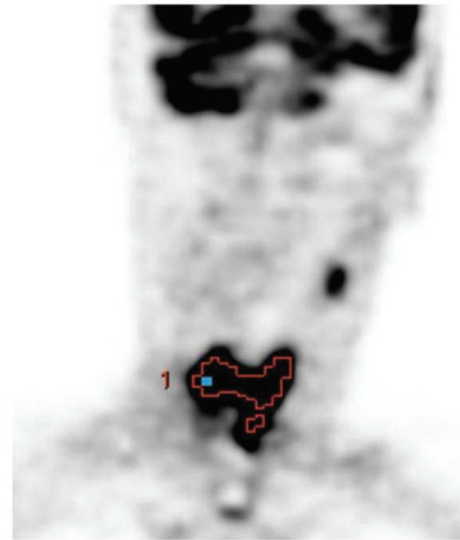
<sup>18</sup>F-2-fluorodeoxyglucose positron emission tomography/computed tomography image of a 67-year-old male with hypopharyngeal squamous cell carcinoma ( $SUV_{max}$ , 26.8;  $SUV_{mean}$ , 16.2;  $SUV_{peak}$ , 18.3; metabolic tumor volume, 27.2; and total lesion glycolysis, 440.6). SUV, standardized uptake value.
